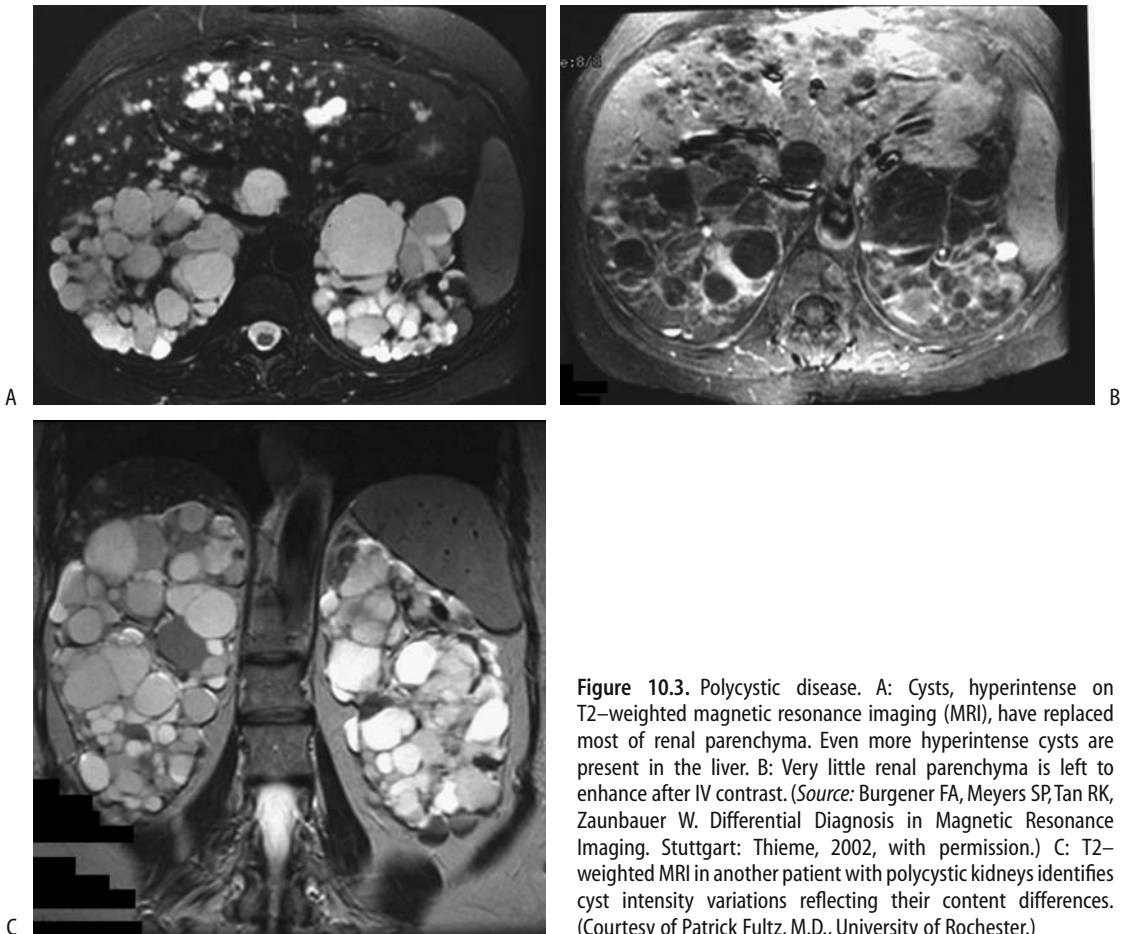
Polycystic disease. A: Cysts, hyperintense on T2-weighted magnetic resonance imaging (MRI), have replaced most of renal parenchyma. Even more hyperintense cysts are present in the liver. B: Very little renal parenchyma is left to enhance after IV contrast. (Source: Burgener FA, Meyers SP, Tan RK, Zaunbauer W. *Differential Diagnosis in Magnetic Resonance Imaging*. Stuttgart: Thieme, 2002, with permission.) C: T2-weighted MRI in another patient with polycystic kidneys identifies cyst intensity variations reflecting their content differences. (Courtesy of Patrick Fultz, M.D., University of Rochester.)
